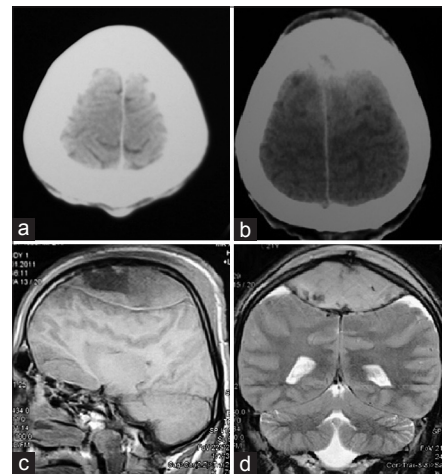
CT imaging at admission (a) and 24th hour post-trauma (b) were both normal. An MRI taken at the 50th hour post-trauma revealed a large vertex epidural hematoma (c, d)
